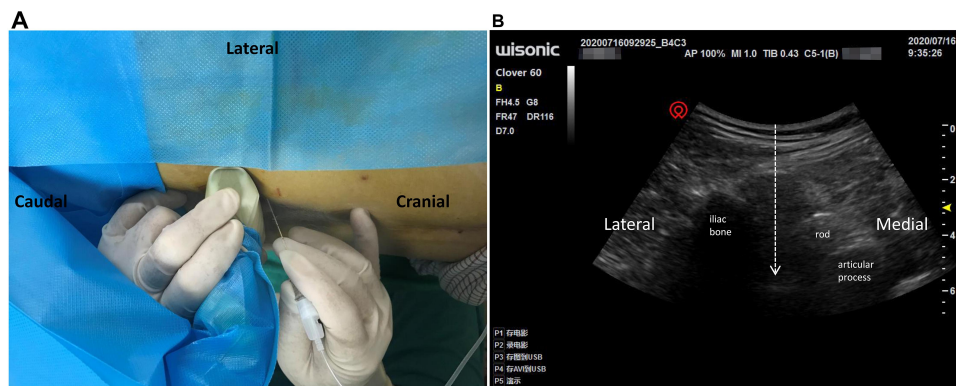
Transducer position and corresponding ultrasound image of L5 PVB. (A) Position of patient, needle, and probe of the ultrasound apparatus under the left L5 PVB. The needle is pointed cephalad-to-caudal toward the target with ultrasound guidance. (B) Transverse ultrasonographic view shows a hyperechoic area between the rod and the iliac bone. The white arrow indicates the out-plane needle path.
